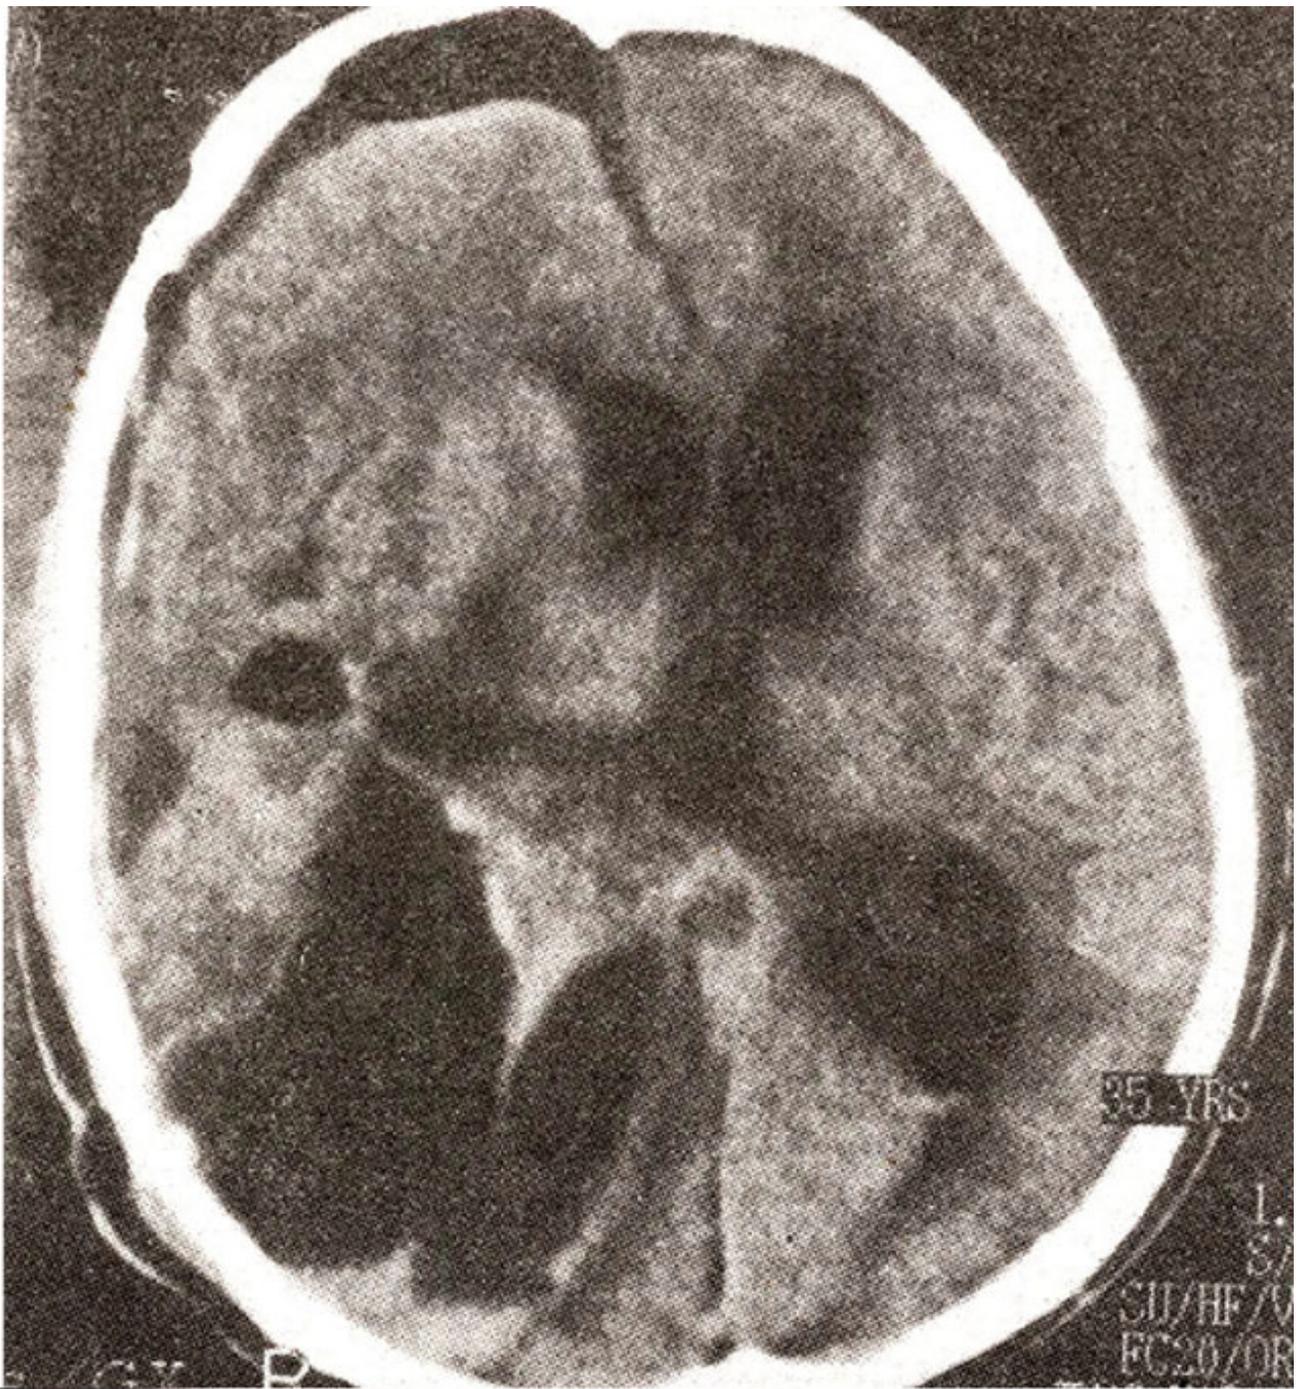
Post operative (2nd day) plain CT head showing complete excision of the multicystic lesion with marked reduction in mass effect.
